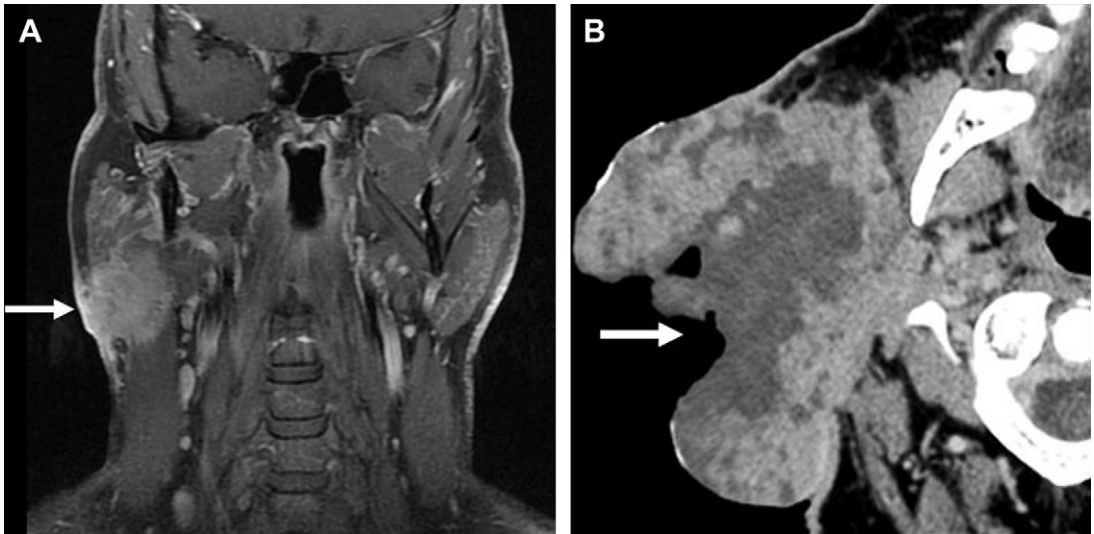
T4a tumors from skin involvement. (A) Coronal postcontrast fat-saturated T1-weighted image shows a right parotid tail mass (*arrow*) that has extended to the skin surface and was visible on physical examination. (B) Axial contrast-enhanced CT shows an exophytic and ulcerated mass (*arrow*) in a different patient that has extended to the skin surface extensively.
